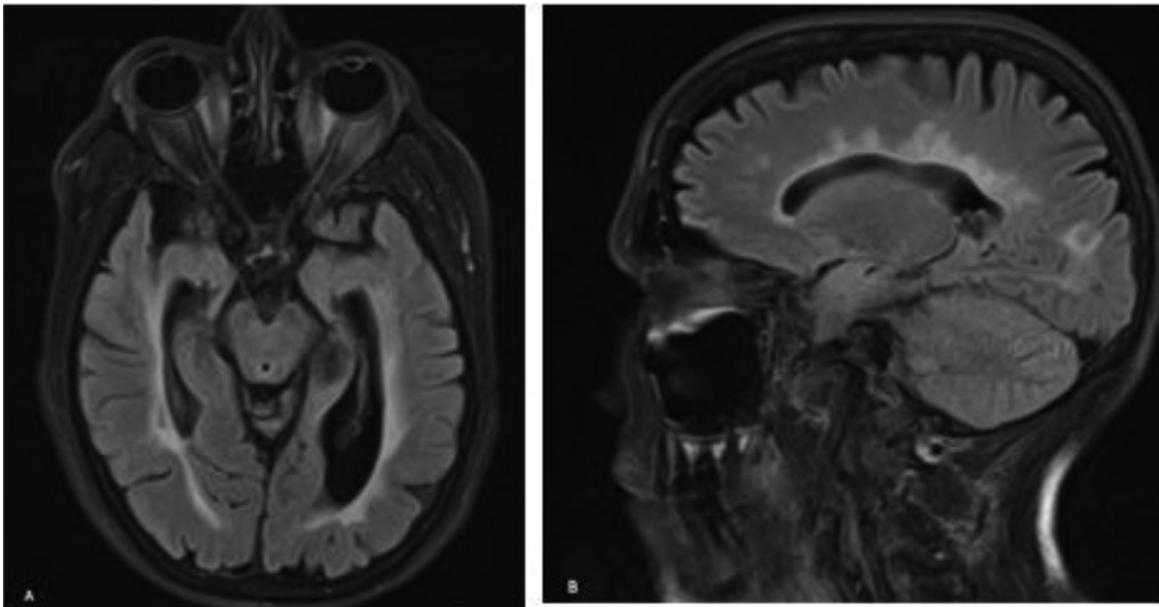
Case 2. Magnetic resonance imaging of the brain with and without contrast material: (A) Fluid-attenuated inversion recovery axial image depicting bilateral optic atrophy; (B) fluid-attenuated inversion recovery sagittal image depicting periventricular and juxtacortical demyelinating lesions.
